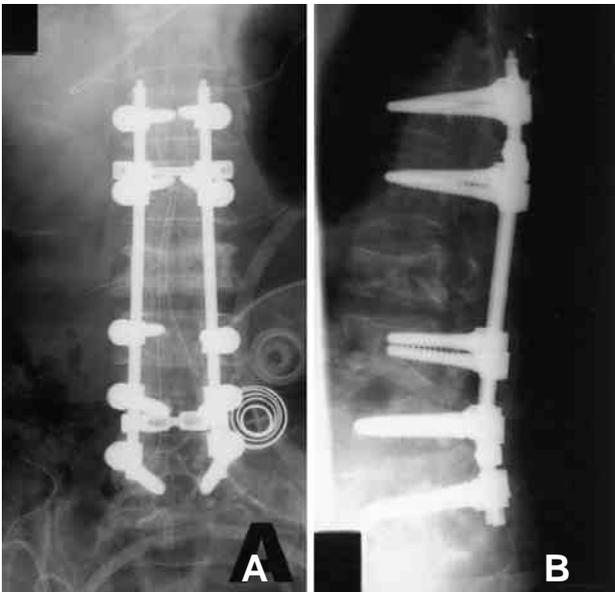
The operation is done with L2-5 decompressive total laminectomy, posterior instrumentation, and fusion. There was no complication during peri- and postoperative period. She started ambulation with TLSO brace since 1 week after surgery. A) is AP and B) is lateral roentgenographic film.
